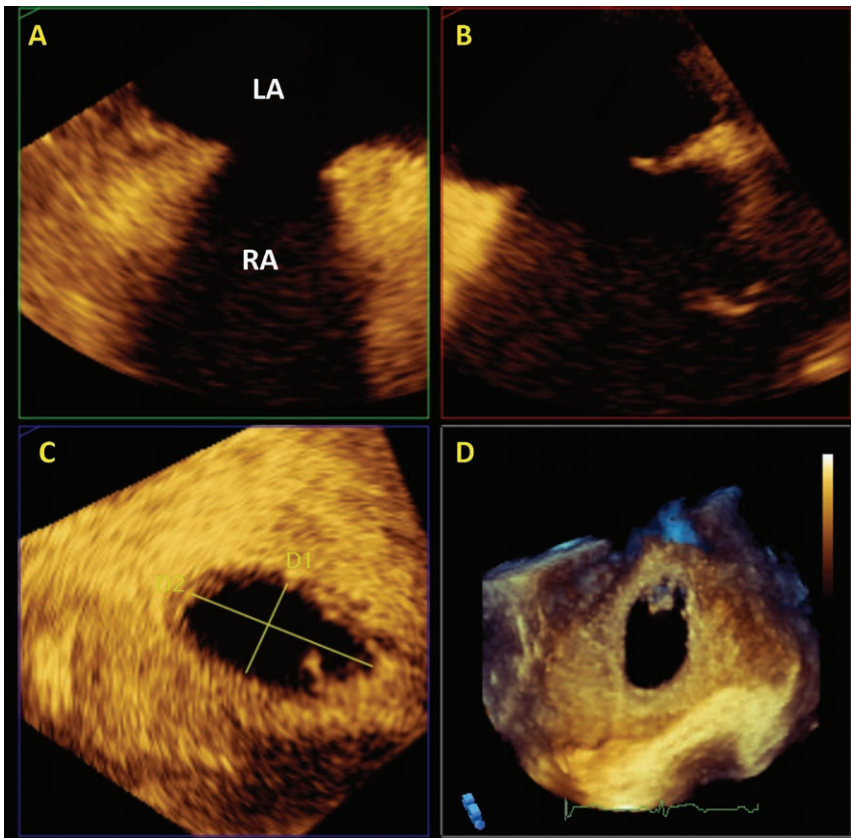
Sizing a secundum atrial septal defect (ASD) by 3-dimensional transesophageal echocardiography (3D TEE). (A-B) Simultaneous long axis views to define the ASD dimensions and geometry. (C) Short axis view of the ASD showing minor (1.2 cm) and major (2.3 cm) diameter of the defect. (D) 3D volume rendered image of the defect as viewed from the left atrium.
